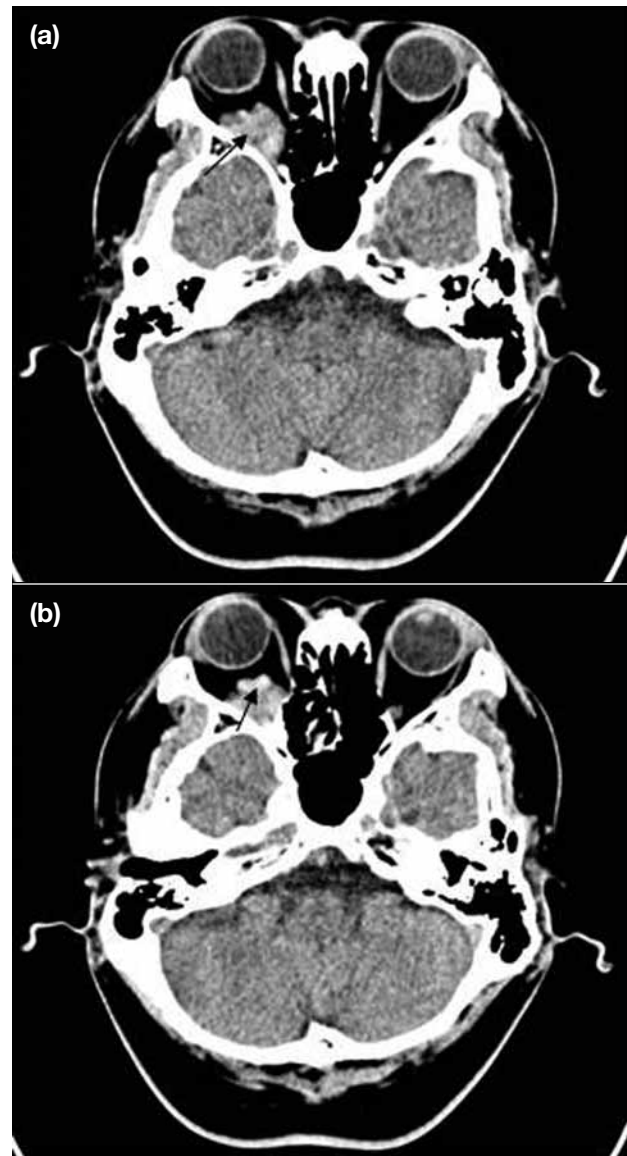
(a) Axial plain computed tomography of the brain shows a hyperdense right retro-orbital lesion with well-defined lobulated margin (arrow) and mild right eye proptosis. (b) A dense and tortuous tubular structure (arrow) is seen at the inferior aspect of the lesion suspicious of a vascular lesion.
